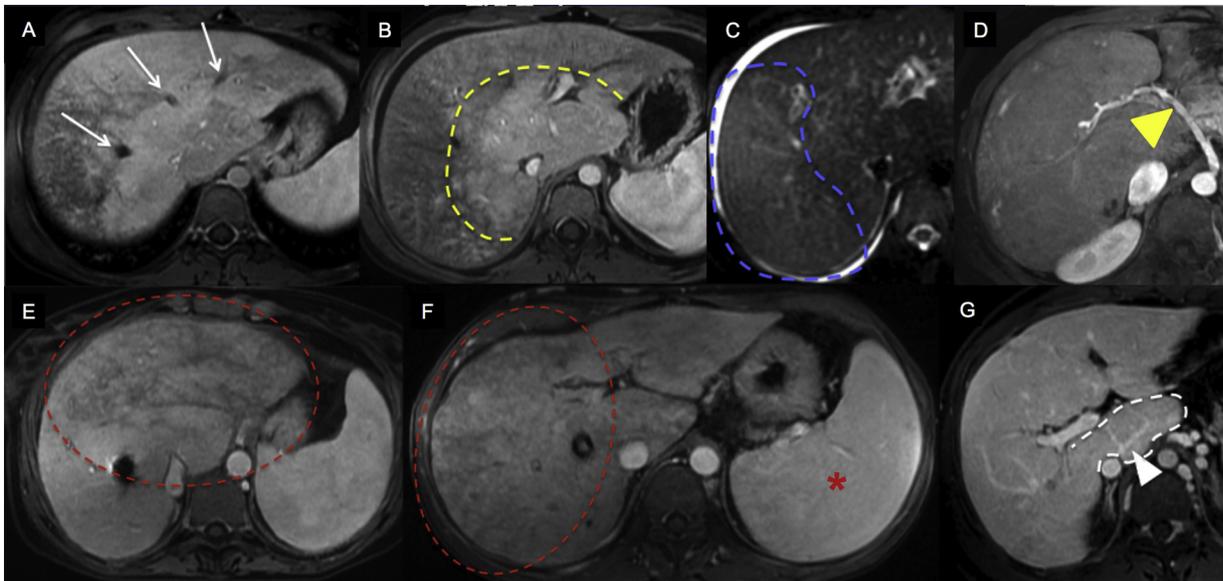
Magnetic resonance imaging (MRI) findings of Budd-Chiari syndrome (BCS). MR images show occlusion of the hepatic veins (white arrows) (a), zonal enhancement (yellow line) (b), peripheral T2 hyperintensity (c), enlarged hepatic artery (yellow arrowhead) (d), mosaic pattern (red circle) (e,f), splenomegaly (red asterisk) (f) and caudate lobe enlargement (white line) (g) with its own venous drainage (white arrowhead).
